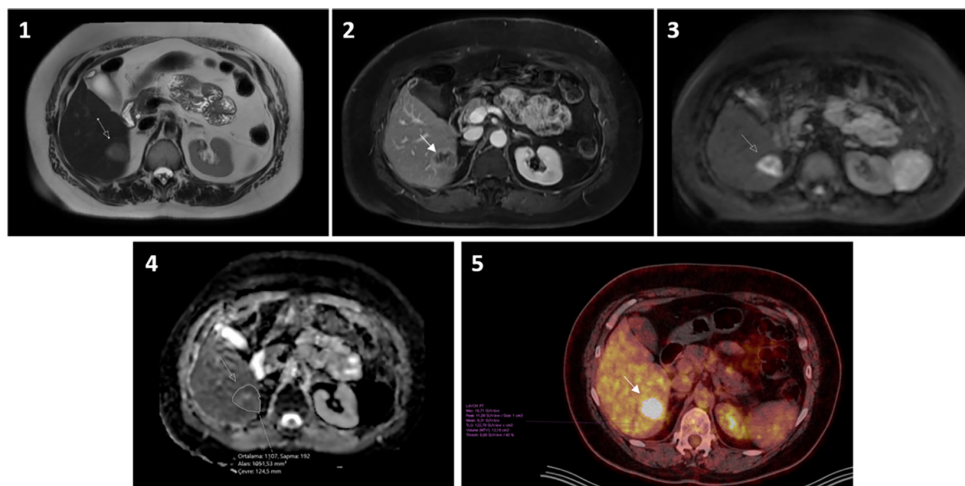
A 46-year-old woman with newly diagnosed metastatic ovarian cancer (1-5) Axial T2, contrast-enhanced fat-suppressed T1, DWI, ADC, and PET/CT images from 1-5 show liver metastasis, respectively (white arrow). The 4th figure shows the ROI for the ADC measurement, and the 5th figure shows the VOI for the SUV measurement. ADC_{min} : $0.73 \times 10^{-3} \text{ mm}^2/\text{s}$, ADC_{mean} : $1.10 \times 10^{-3} \text{ mm}^2/\text{s}$, ADC_{max} : $1.79 \times 10^{-3} \text{ mm}^2/\text{s}$, SUV_{mean} : 9.3, SUV_{Mean} : 11.1, SUV_{max} : 16.7 were calculated.
